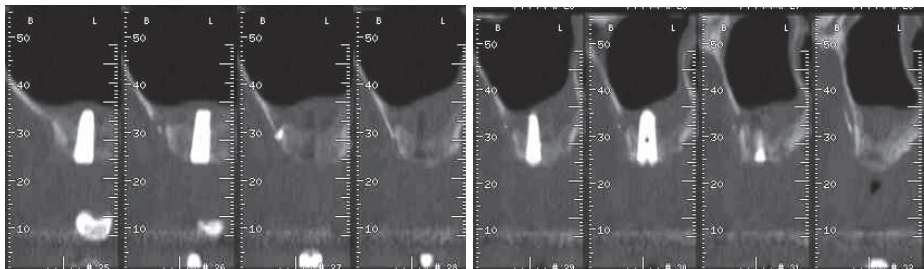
(left) and 67. (right). CT scan shows bone reformation in the sinus after 6 months healing.
